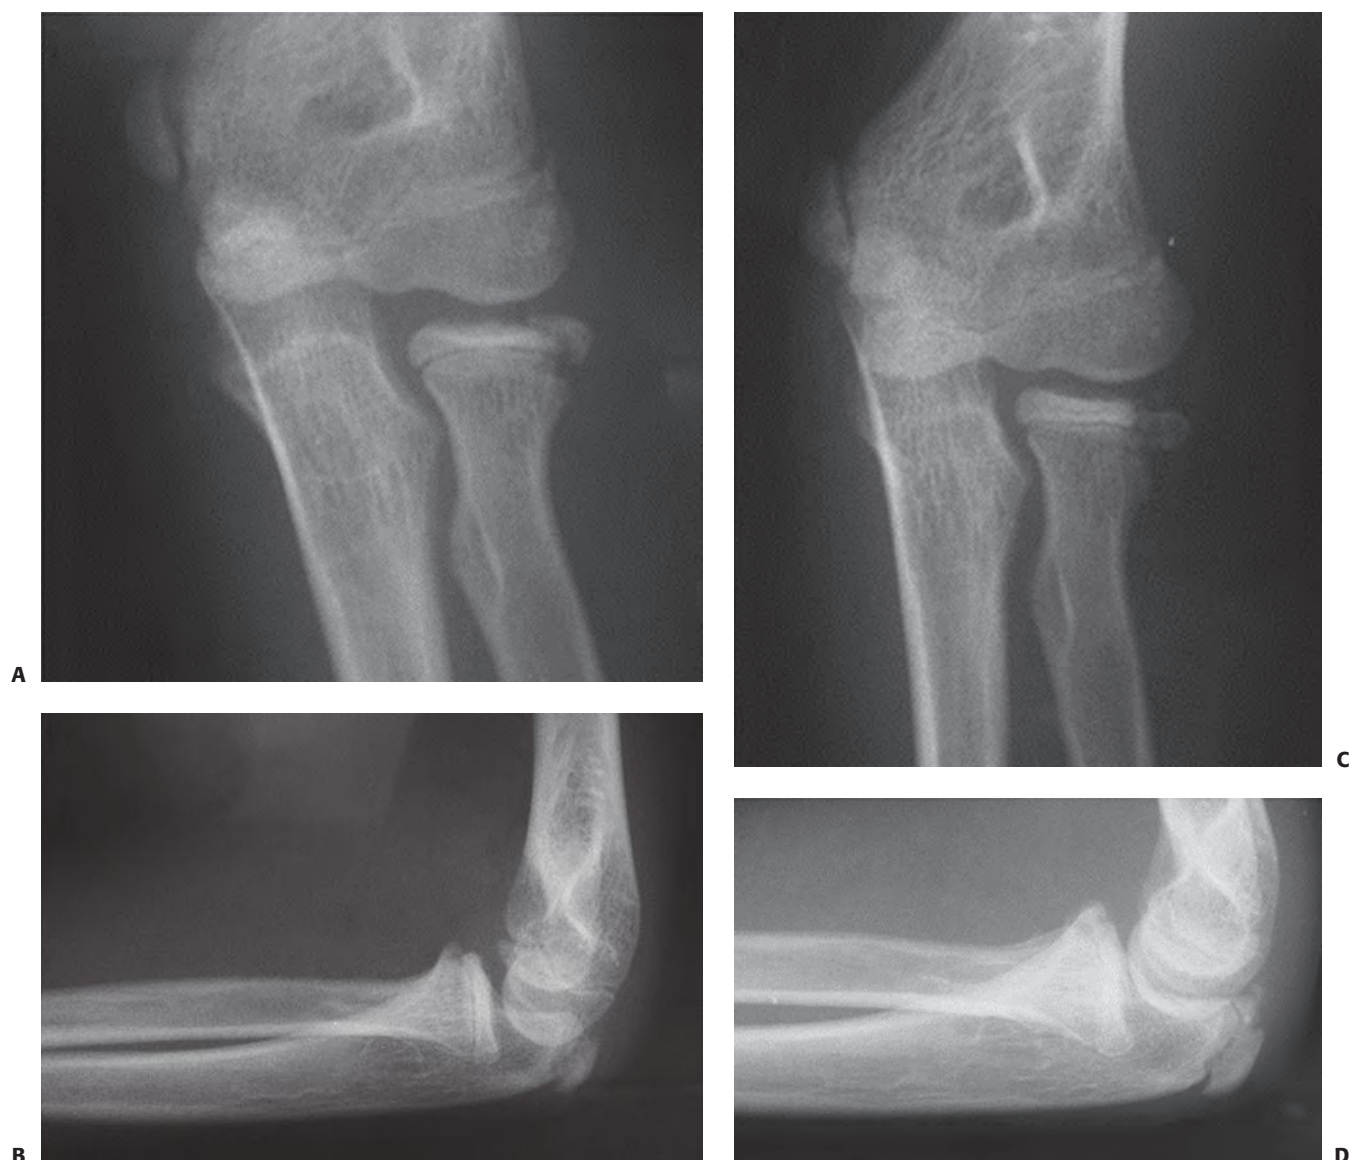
A 13-year-old male patient after fall on pronated outstretched hand. A, B: Anteroposterior and lateral radiographs of the injured elbow. Salter–Harris III fracture of radial epiphysis without evidence of subluxation. C, D: Anteroposterior and lateral radiographs 6 weeks after the injury. No evidence of osseous union with posterolateral subluxation.
